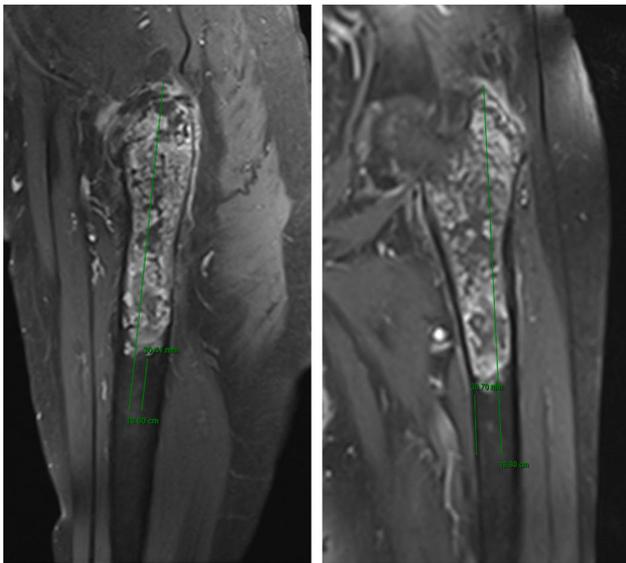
Representative electronic measurement method on MRI. T1 weighted fat-suppressed MRI of a chondrosarcoma of the left proximal femur in a sagittal plane (left) and coronal plane (right). The resected length of bone in this patient was 18.8 cm indicated by the longer green line in each panel.
